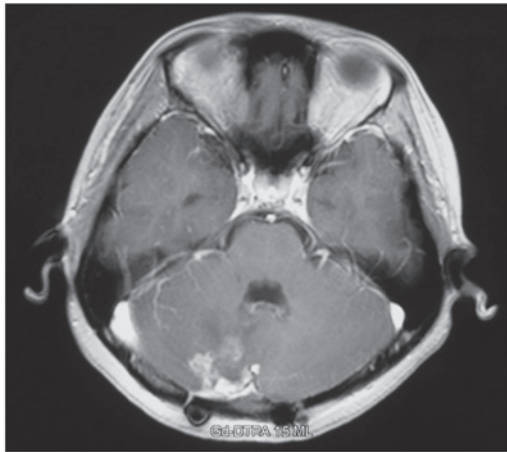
Axial magnetic resonance imaging scan of the brain shows an annular focal high-intensity signal in the region of the right cerebellar hemisphere.
